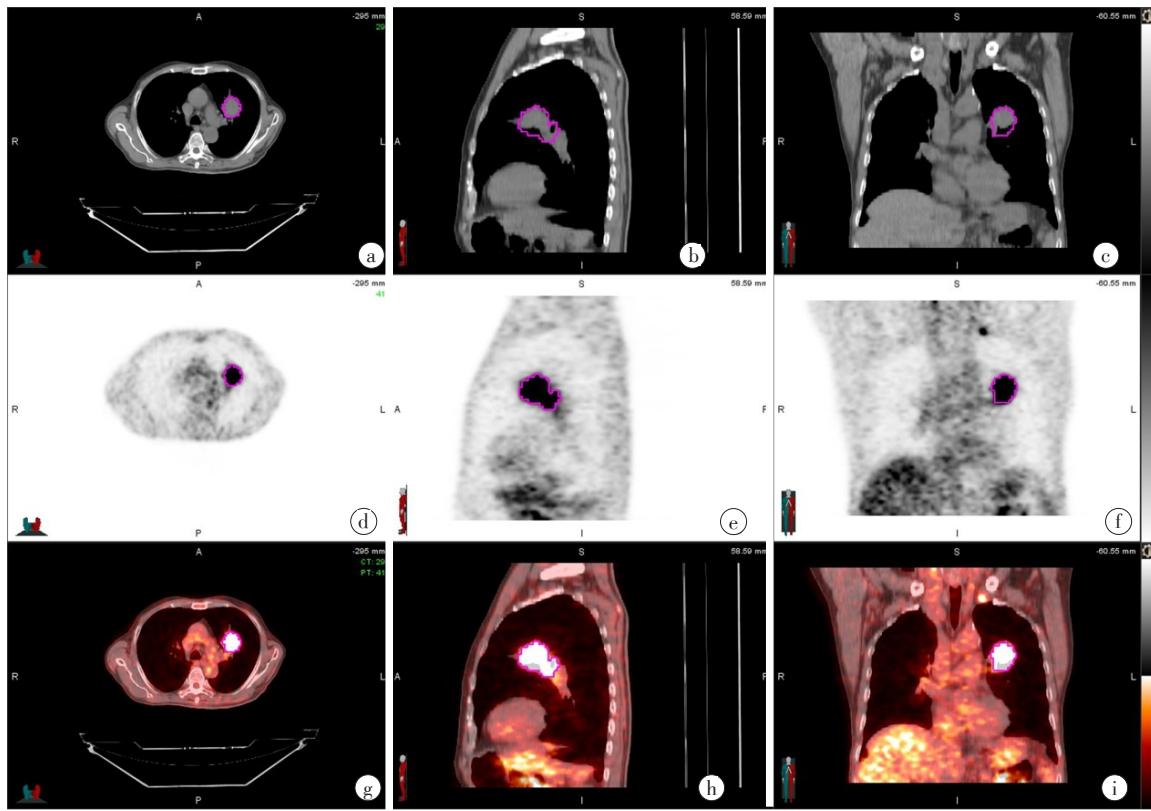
CT、¹⁸F-FDG PET 和 ¹⁸F-FDG PET/CT 显示治疗前肿瘤图像
